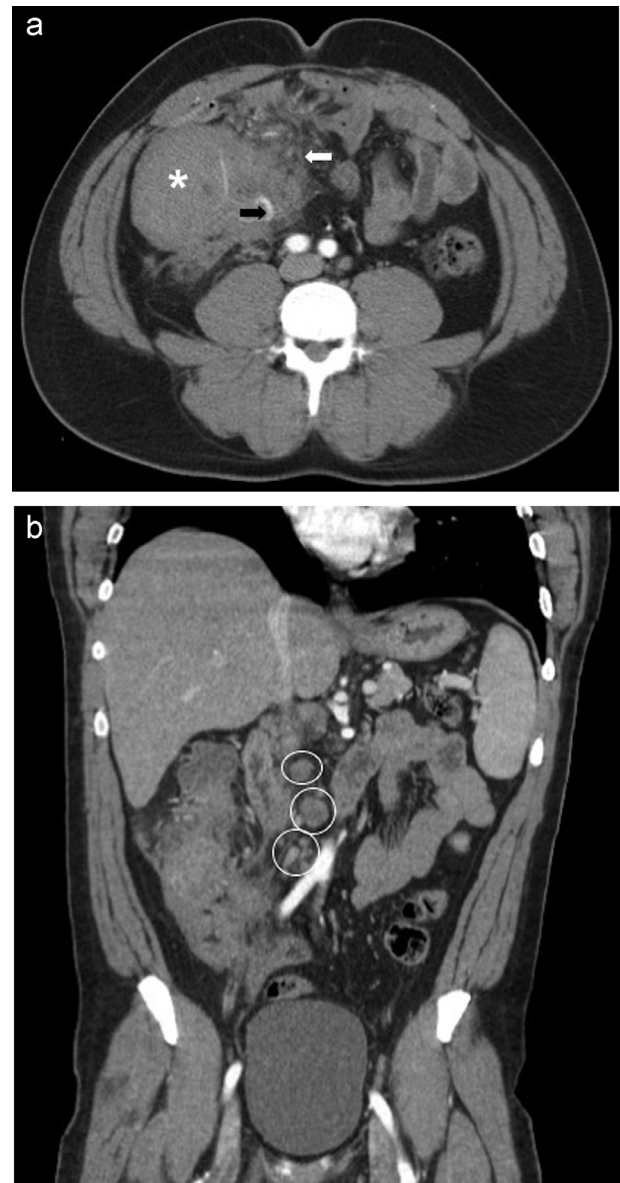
Axial CT image (1.25 mm section thickness) after administration of intravenous iodinated contrast media in the late hepatic arterial phase (a), showing marked mural thickening of the cecum, forming a mass (asterisk) that encases branches of the ileocolic artery (black arrow), without obliteration. Note the substantial fat stranding (white arrow). (b) Coronal reconstruction (3 mm section thickness) of the late hepatic arterial phase showing the same aspects and also the presence of regional mesenteric lymphadenopathies—circles.
